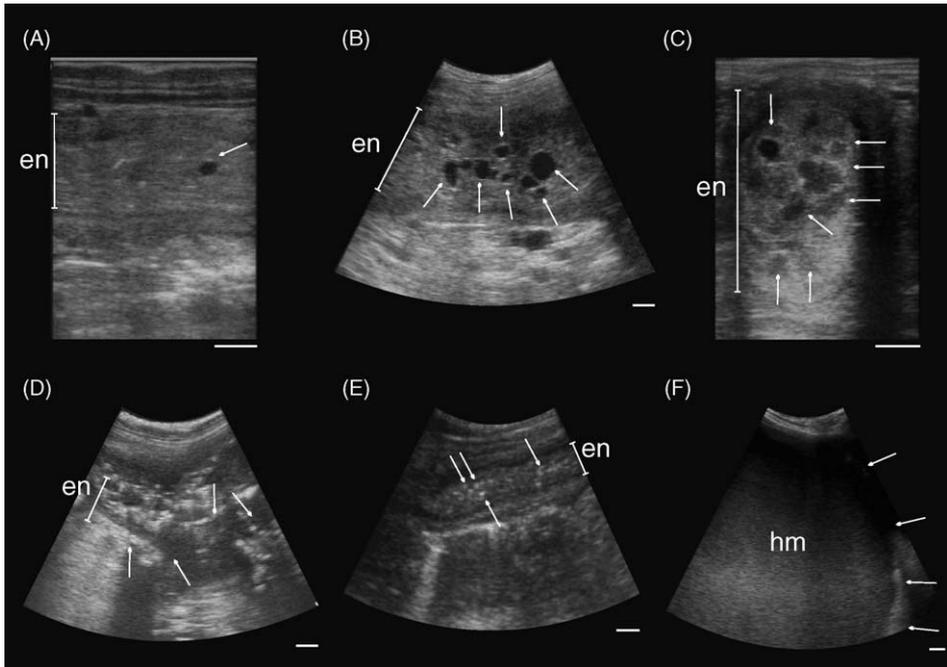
Ultrasonographic images of the uterus in white rhinoceroses showing different stages of cystic hyperplasia in the endometrium (en). (A) A singular fluid-filled cyst (arrow) in a cycling, primiparous 30-year-old female, no. 230. (B) Multiple fluid-filled cysts (arrows) in a cycling nulliparous 20-year-old female, no. 652. (C) Multiple confluating cysts with fluid-filled and medium echogenic cavities (arrows) in a non-cycling, nulliparous 20-year-old female, no. 1154. (D) Multiple confluated cysts with increased amount of fibrotic areas (arrows) in a non-cycling nulliparous 25-year-old female, no. 476. (E) Endometrial fibrosis (arrows) in a senile non-cycling, nulliparous 30-year-old female, no. 243. (F) Hydromucometra (hm): fluid filled cavity of the uterus (arrows) in 30-year-old female, no. 366. Scale bars represent 1 cm.
